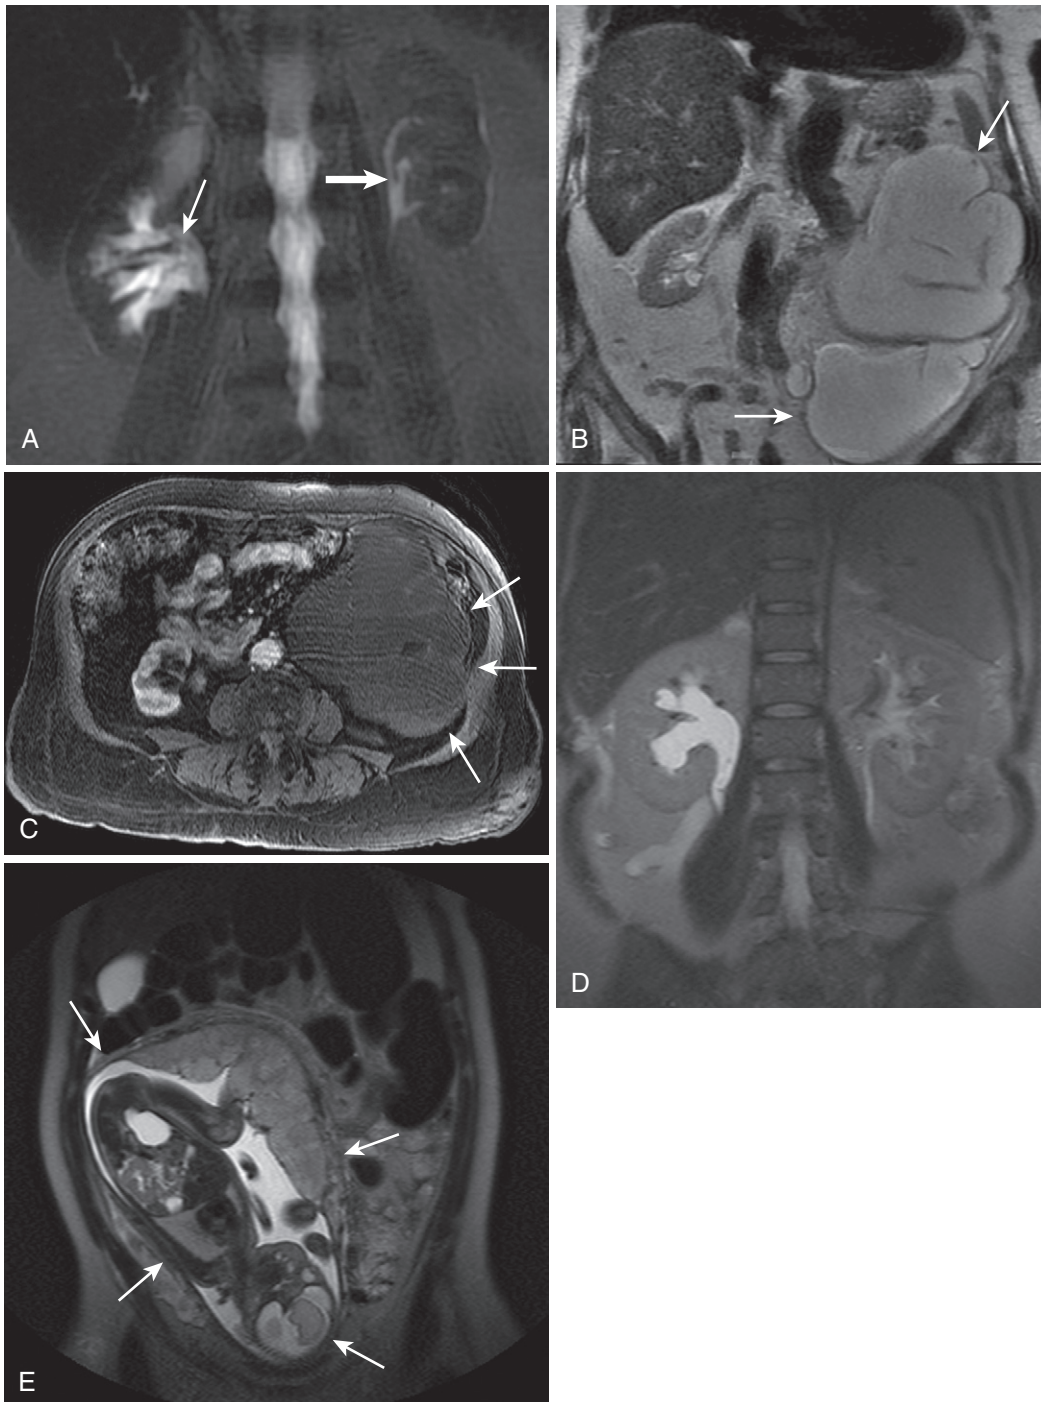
Hydronephrosis. A, The heavily T2-weighted magnetic resonance urography (MRU) image shows asymmetrical right-sided collecting system (*thin arrow*) compared with the normal left-sided collecting system (*thick arrow*) in a patient with mild hydronephrosis. The coronal heavily T2-weighted single-shot fast spin-echo (SSFSE) image (B) portrays an example of severe, longstanding left-sided hydronephrosis (*arrows*), and the axial postcontrast image (C) shows the thinned, virtually obliterated, nonenhancing rim of nonfunctioning enhancement (*arrows*). Mild to moderate right-sided hydronephrosis is apparent on the coronal T2-weighted image in a different patient (D) due to the mass effect of the gravid uterus, as seen on a more caudally positioned T2-weighted image (*arrows* in E).
